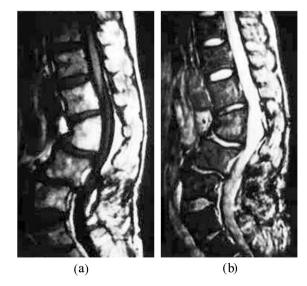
Sagittal view of lumbar spine MRI before surgery. (a) T1-weighted image. (b) T2-weighted image. Disc space of the block vertebra showed a complete defect. No spinal canal stenosis is present.
